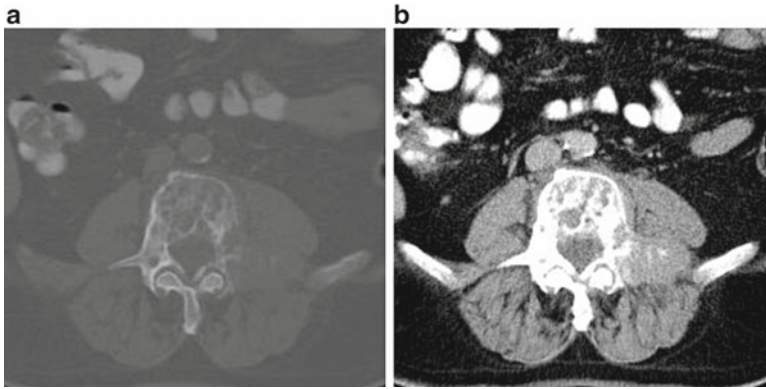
CT presenting destructive lytic lesion of L5 due to a metastasis from prostatic cancer (a) accompanied by soft tissue mass enhancing after IV contrast administration (b)
